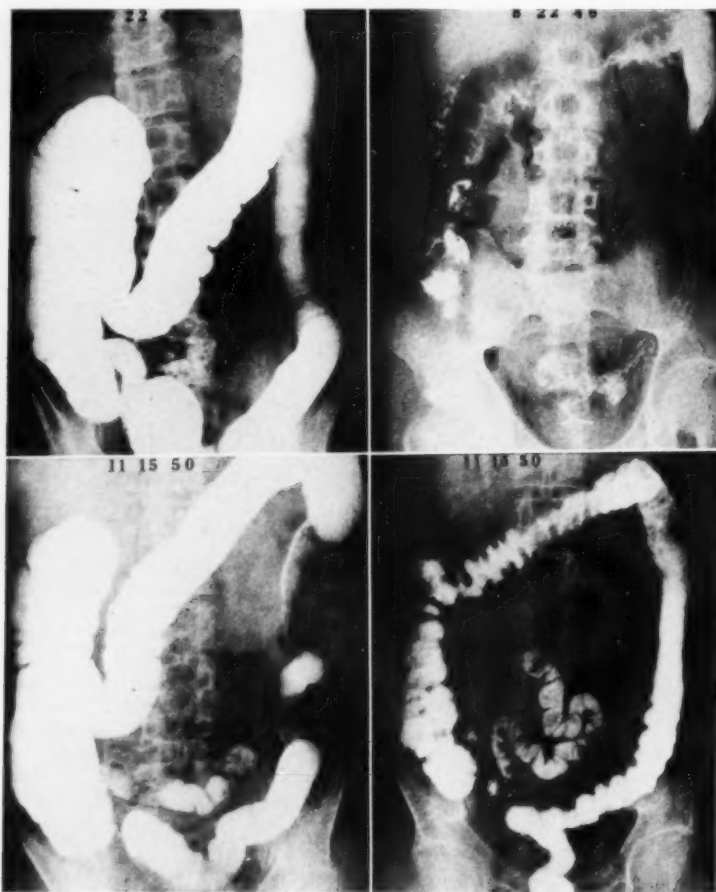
M. U. Improvement in roentgen appearance of colon. Complete clinical recovery.
